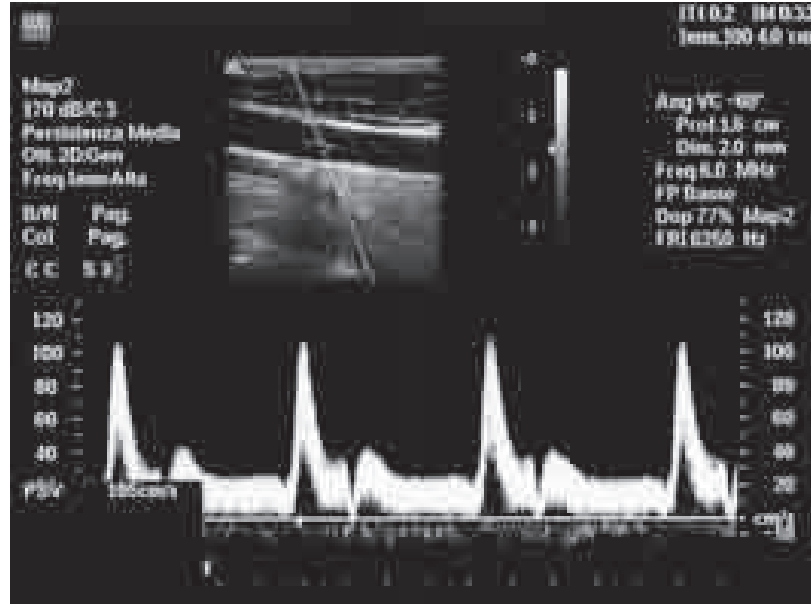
Typical display of the conventional spectral estimation in duplex mode. The B-mode image of the investigated region, with superimposed Doppler line, angle cursor, and SV, is shown on top. The spectrogram corresponding to the SV is displayed on the bottom and the average PSV, calculated from the spectrogram peaks, is shown in the bottom-left corner. Note that the SV here is long about 2 mm.
